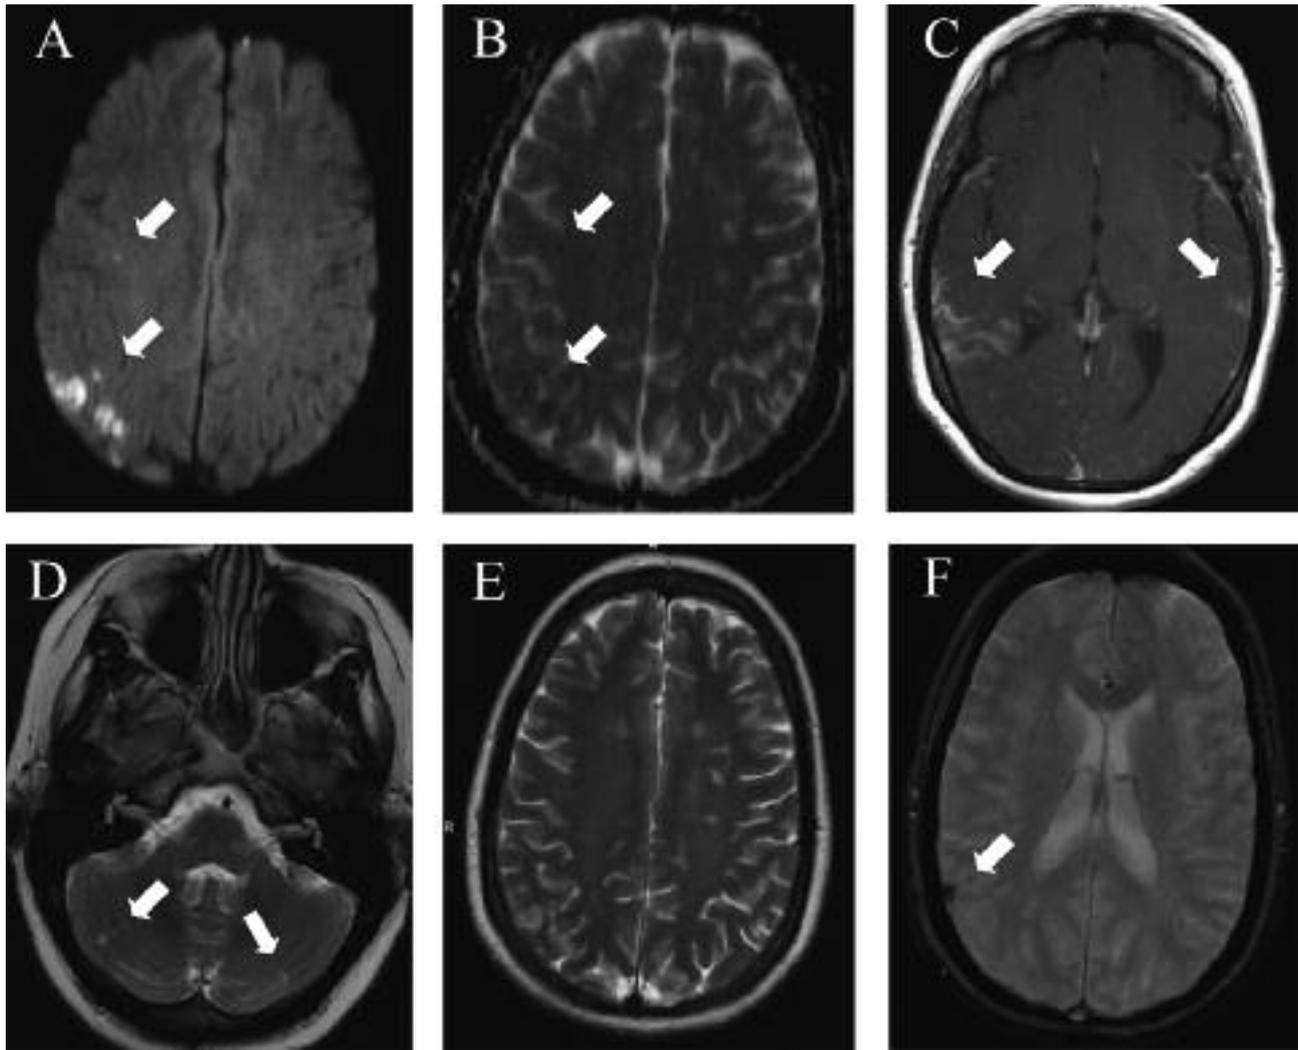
Hyperintensities in the right parietal and frontal lobes on axial diffusion-weighted ( $b = 1000$ ) MRI (arrows, A) with corresponding hypointensities on the apparent diffusion coefficient map (arrows, B) indicating acute cerebral ischemia. Abnormal gadolinium enhancement in the right temporoparietal region and left temporal lobe on axial T1-weighted sequence (arrows, C) suggestive of blood-brain barrier disruption in subacute ischemia. Cerebellar signal changes indicating chronic ischemia (arrows, D) and multiple supratentorial WML (E) on axial T2-weighted sequence. Hypointensity (arrow, F) suggestive of cerebral haemorrhage on axial T2\*-weighted sequence.
